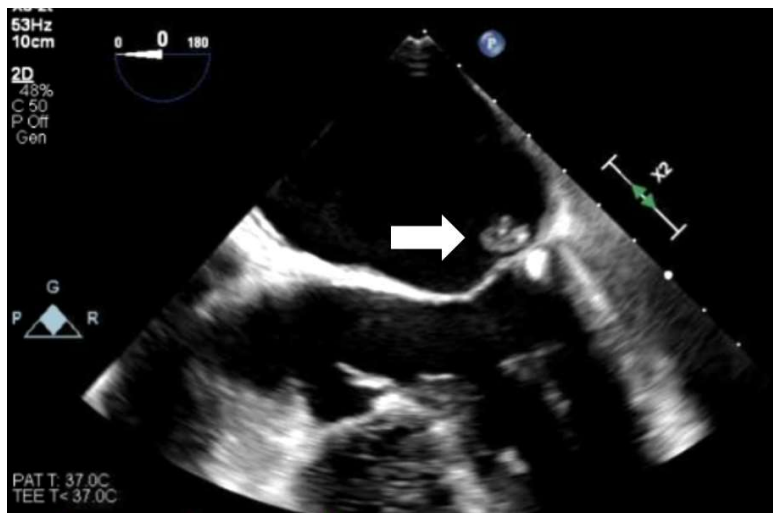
Legend: Transesophageal Echocardiogram showing thickening of the posterior mitral leaflet. An atrial surface mitral valve mobile vegetation of 12mm diameter.
